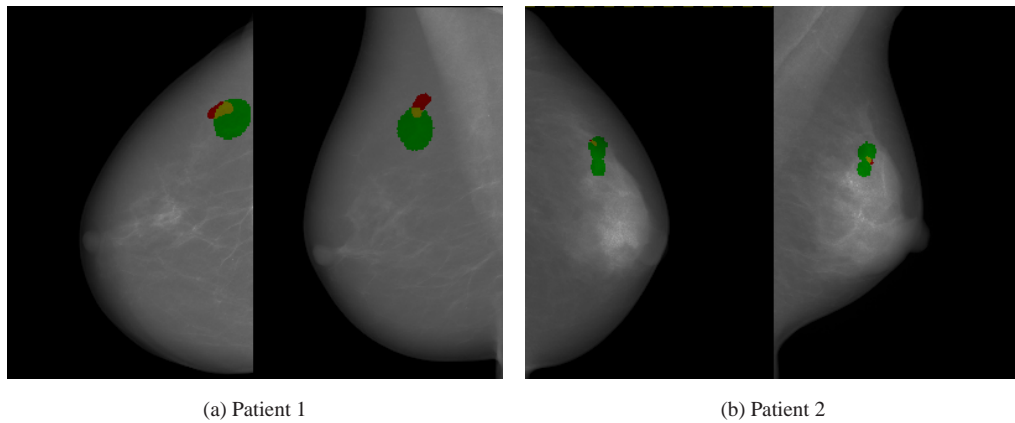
CC (on the left) and MLO (on the right) mammogram of patients 1 and 2. The X-ray mammogram annotation is shown in red and the projection of the MR annotation in green. (a) Patient 1 was diagnosed with an Invasive Ductal Carcinoma; the registration error is $8.12mm$ for the CC and $14.43mm$ for the MLO view. (b) Patient 2 diagnosed with Ductal Carcinoma In Situ; the registration error is $6.85mm$ for the CC and $2.63mm$ for the MLO view.
